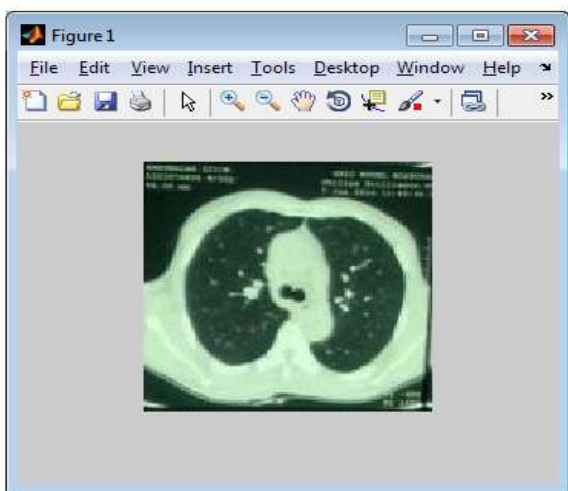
Original MRI image (255x255)
